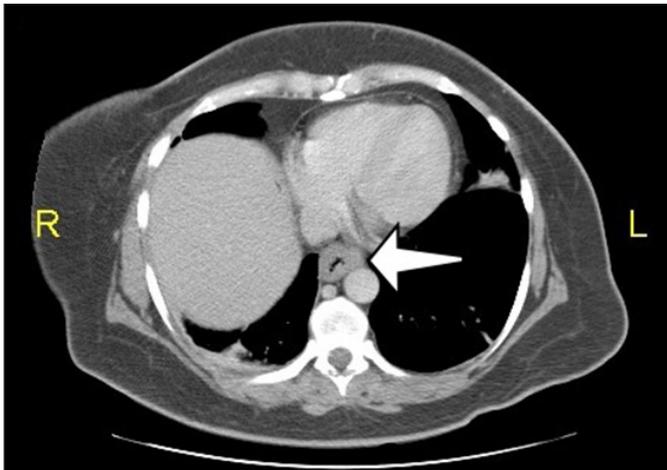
Abdominal CT of the lower esophagus showing a thickened esophagus (arrow).
